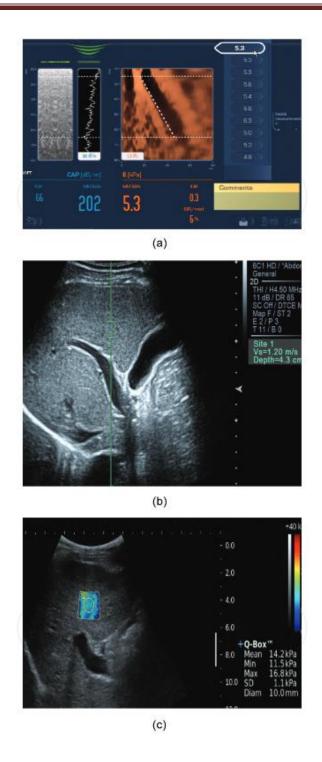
Currently available ultrasound-based shear wave elastography methods for the liver. (a) Transient elastography (TE) (b) Point shear wave elastography (pSWE) (c)
